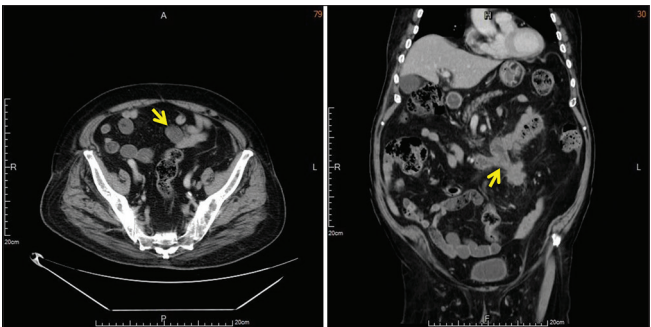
Abdominal computed tomography demonstrated a neoplasm (yellow arrow) over sigmoid colon invaded to the duodenum fourth portion
